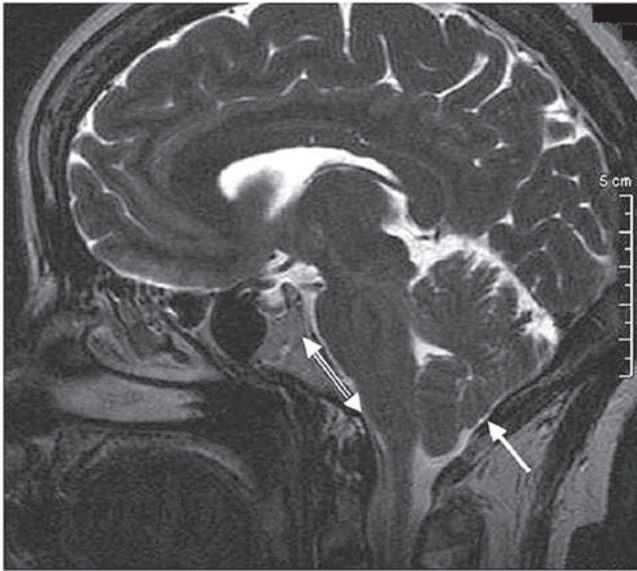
A sagittal T2-weighted image shows basiocapital hypoplasia with Chiari type-I malformation (*single arrow*) and a shortened clivus (*double arrow*). (From Noudel R, Jovenin N, Eap C, Scherpereel B, Pierot L, Rousseaux P. Incidence of basiocapital hypoplasia in Chiari malformation type I: comparative morphometric study of the posterior cranial fossa. *J Neurosurg* 2009;111:1046–1052. Reprinted by permission.)
